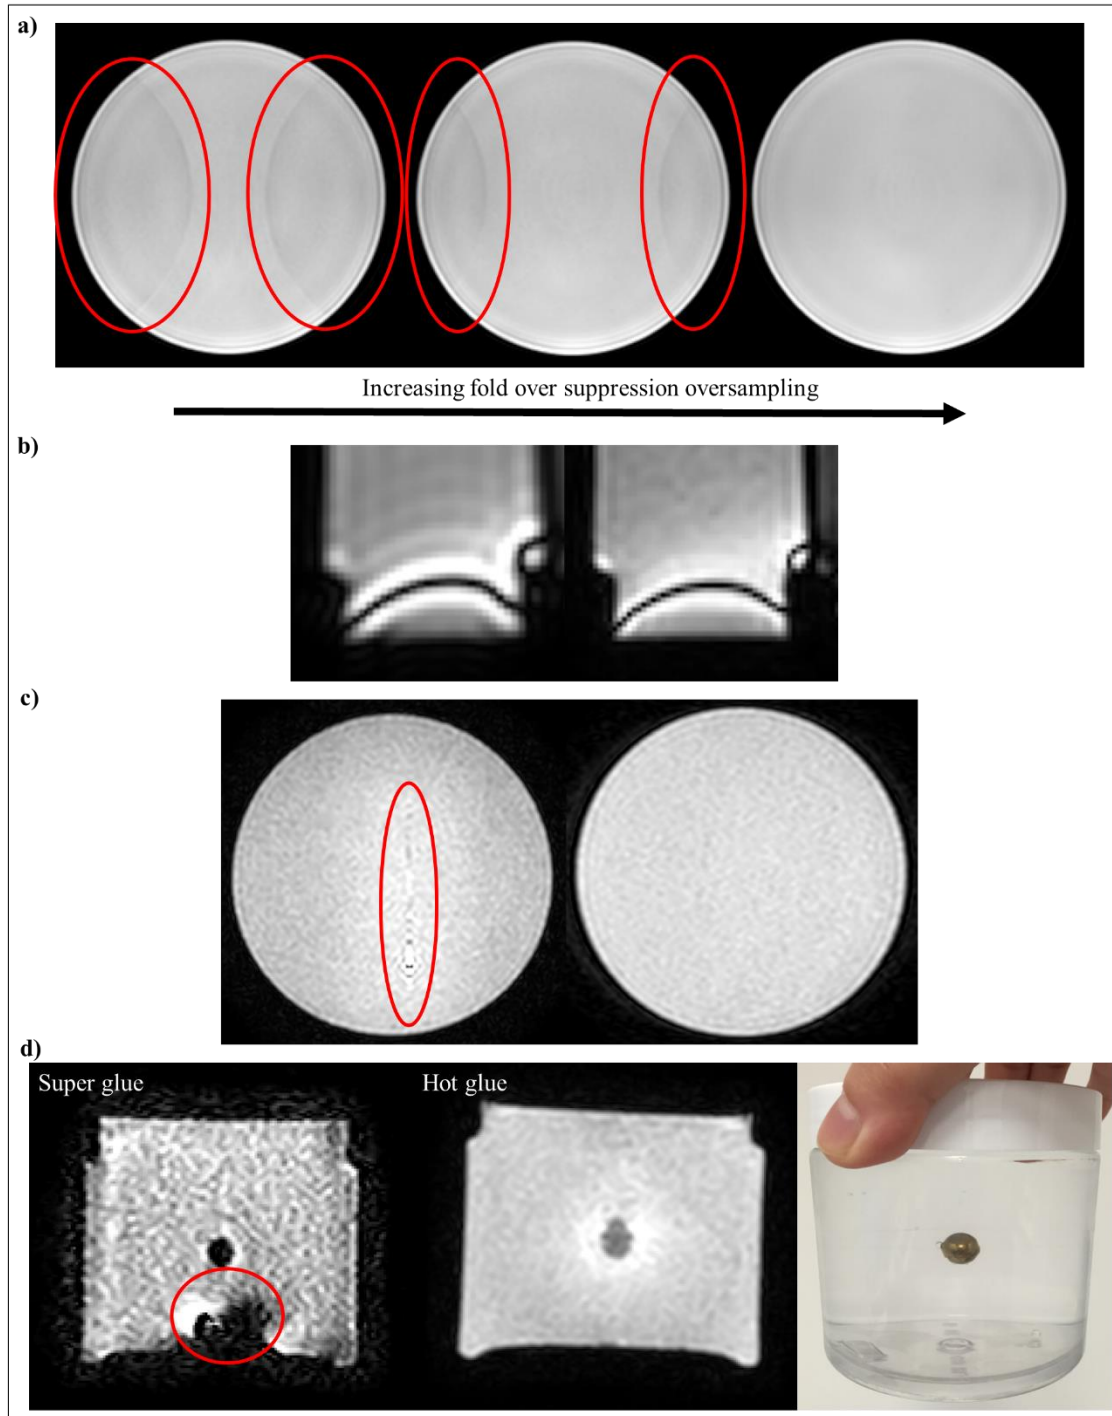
Examples of MRI artifacts. a) Fold over artifacts that could be remedied with suppression oversampling or increased field of view, b) Gibbs ringing artifact that could be reduced in the gel on the right but could never be completely removed due to arising from the fundamental consequence of using Fourier transform to reconstruct MR signals into images, c) zipper artifact that generally occurs with radiofrequency contamination from electronic devices occurred with spin echo sequences in PET plastic (with gel or water) and remedied on the right with a turbo spin echo sequence, and d) MR artifact due to super glue on bottom of jar (regardless of gel or water) but not present when hot glue was used. Central black region was due to brass ball bearing.
